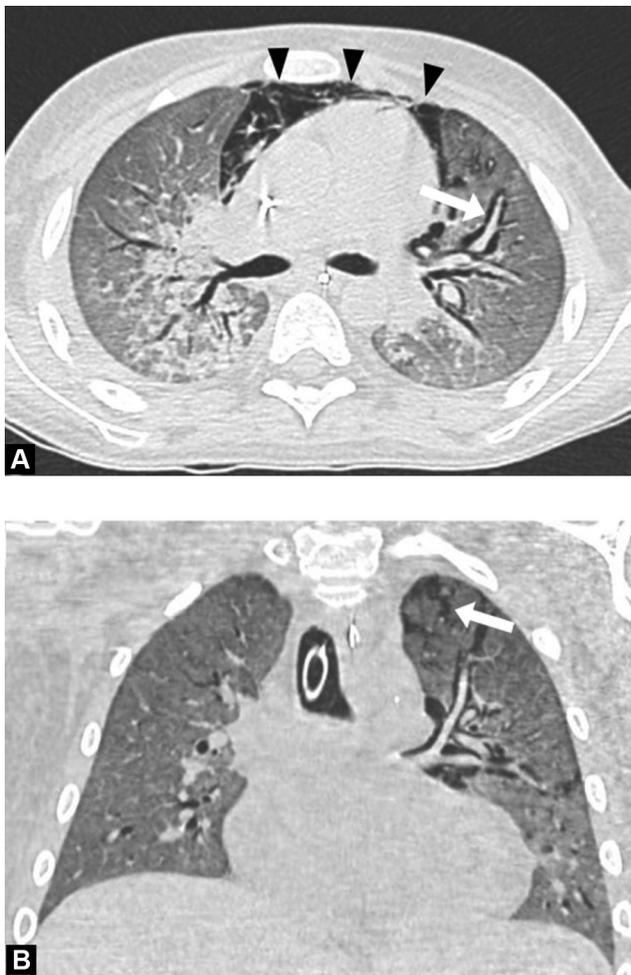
A 12-year-old boy presenting with pulmonary interstitial emphysema. A. Computed tomography (CT) image in the transverse plane shows abnormal location of air, surrounding pulmonary artery branches (arrow) and pneumomediastinum (arrowheads). B. CT image in the coronal plane shows air-trapping aspect in the peri-lobular interstitium (arrow).
